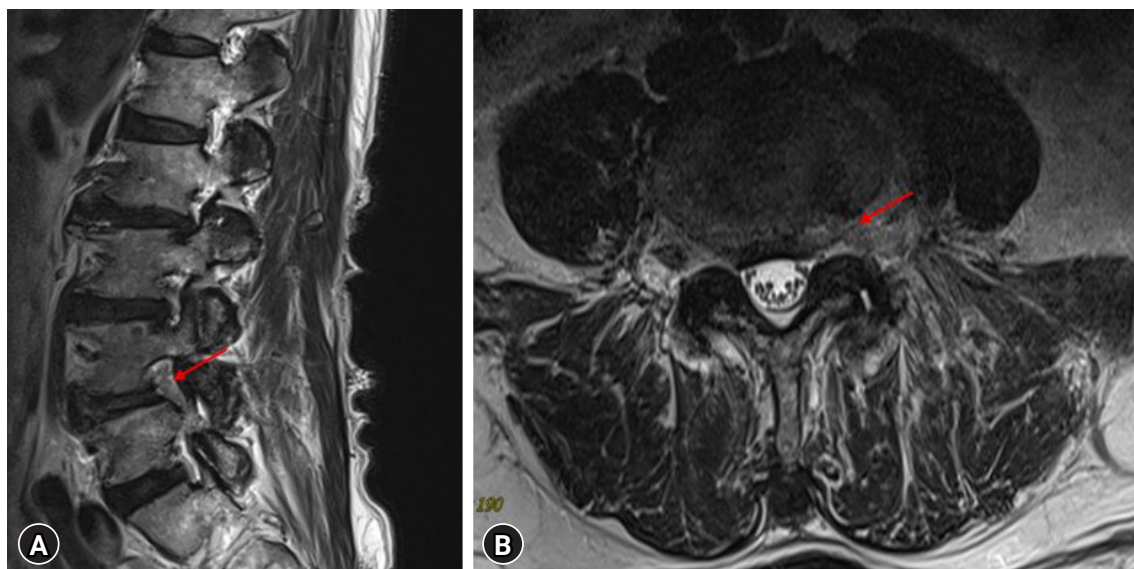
Postoperative magnetic resonance imaging sagittal view (A) and axial view (B) showing adequate decompression at the L4–5 level after endoscopic discectomy (arrows).
